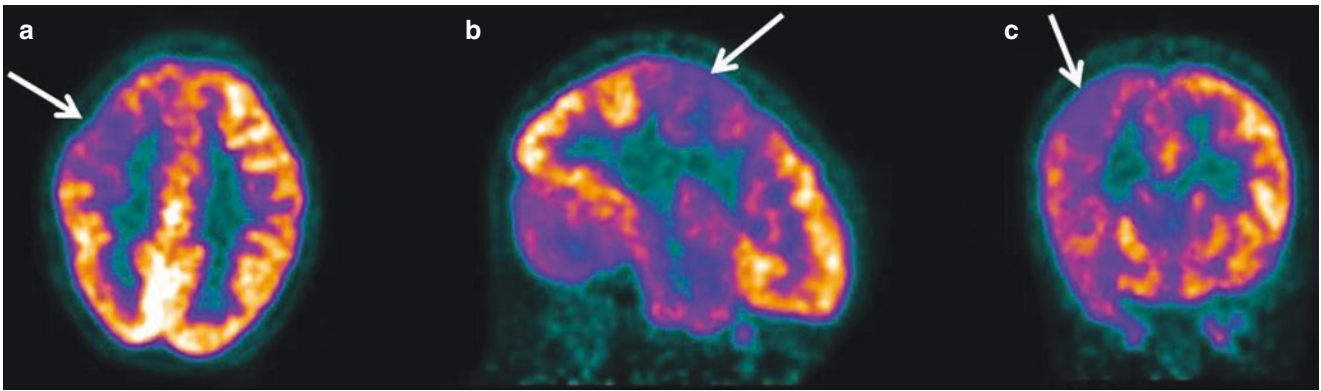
Interictal ^{18}F -FDG PET/CT brain scan of a 7-year-old girl with medically refractory epilepsy. Transverse (a), sagittal (b), and coronal (c) views of the brain showing diffuse hypometabolism at the posterior right frontal lobe extending to the right parietal lobe (*arrow*)
